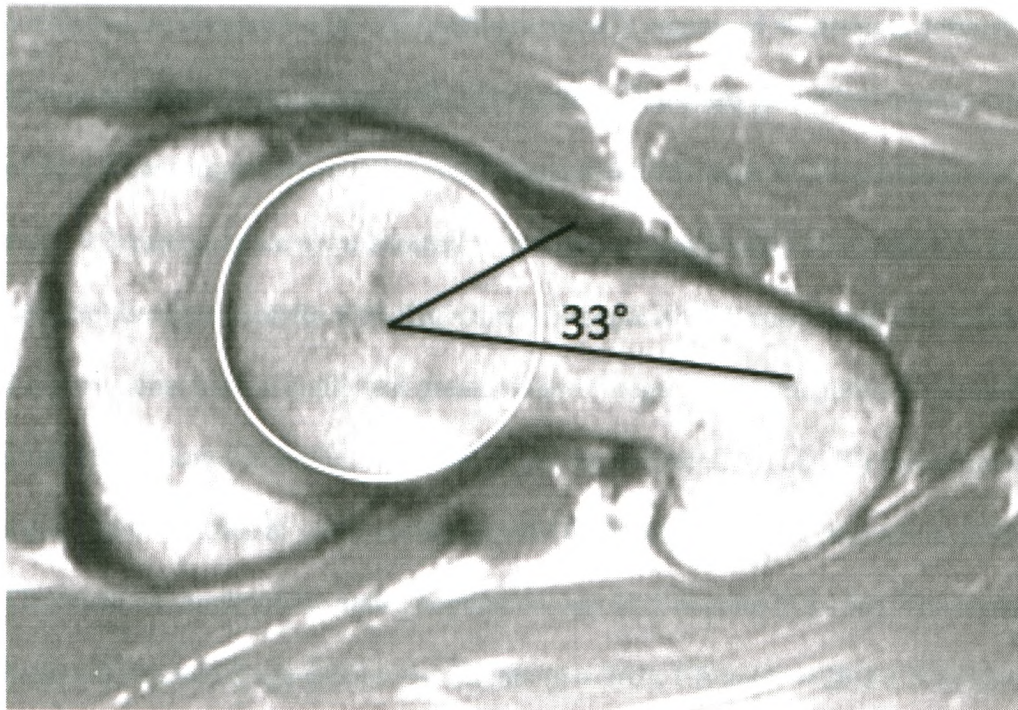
A normal alpha angle measurement on an MR image of a 25-year-old male. As established by Notzli et al. (7), normal alpha angles range from 33 to 48 degrees.
